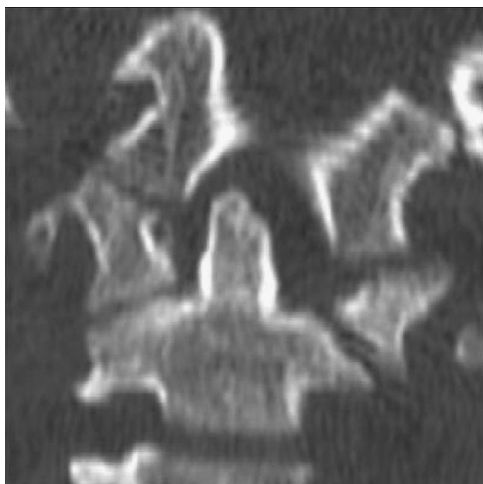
Noncontrast CT in a 4-year-old girl with symptoms of atlantoaxial rotatory fixation demonstrates an asymmetric LAI: 2.6 mm on the right and 8.5 mm on the left. The difference of 5.9 mm is abnormal based on our results. This helps to confirm atlantoaxial rotary fixation.
